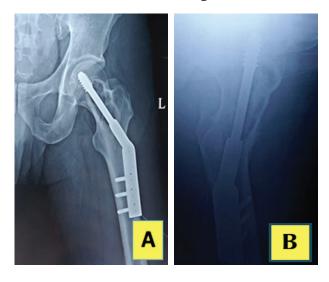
Postoperative X-ray left hip AP View (A) & lateral view (B) showing osteosynthesis in left proximal femur.
